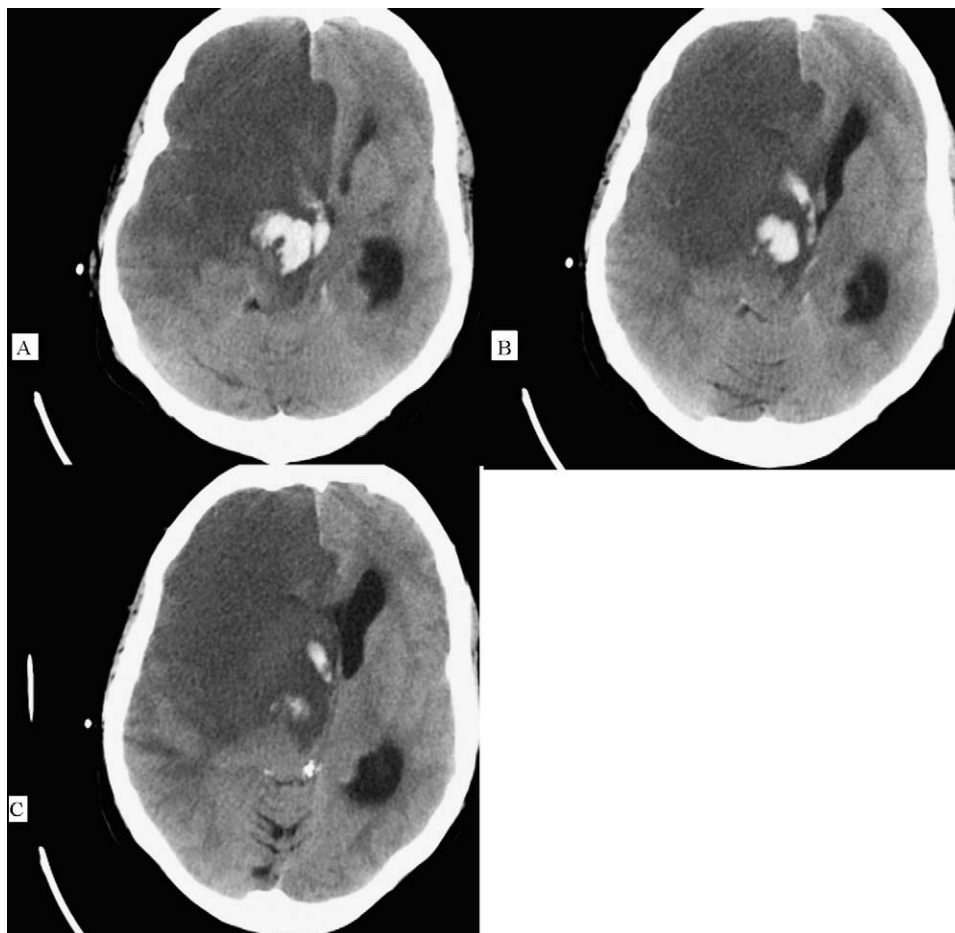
Axial computed tomography scan showing large right hemispherical brain ischemia (A–C).
